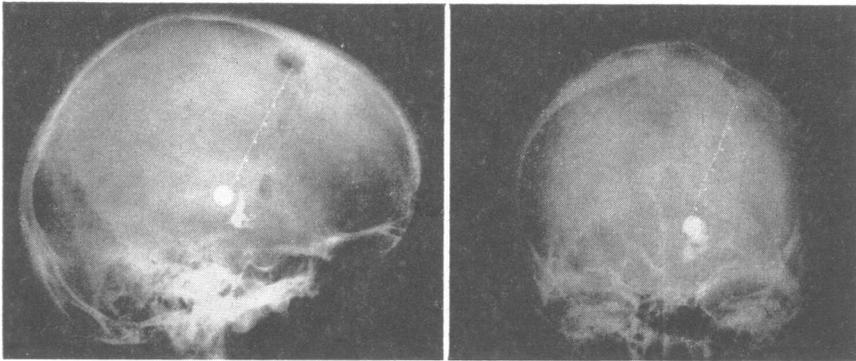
Roentgenographic demonstration of alcohol-Pantopaque pallidectomy lesion followed by insertion of balloon cannula into the thalamus in Case IV.
